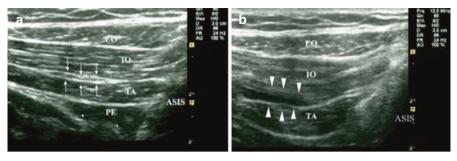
Ultrasound pictures showing the fascia split before and after injection of a local anesthetic. (a) Ultrasound picture showing the three layers of abdominal muscle and the ilioinguinal and iliohypogastric nerves in the fascia split (*arrows*) between internal oblique and transversus abdominus muscles. (b) Presence of local anesthetic in the fascia split following injection. *EO* external oblique muscle, *IO* internal oblique muscle, *TA* transversus abdominus muscle, *PE* peritoneum, *ASIS* anterior superior iliac spine (Reproduced with permission from Philip Peng Educational Series)
